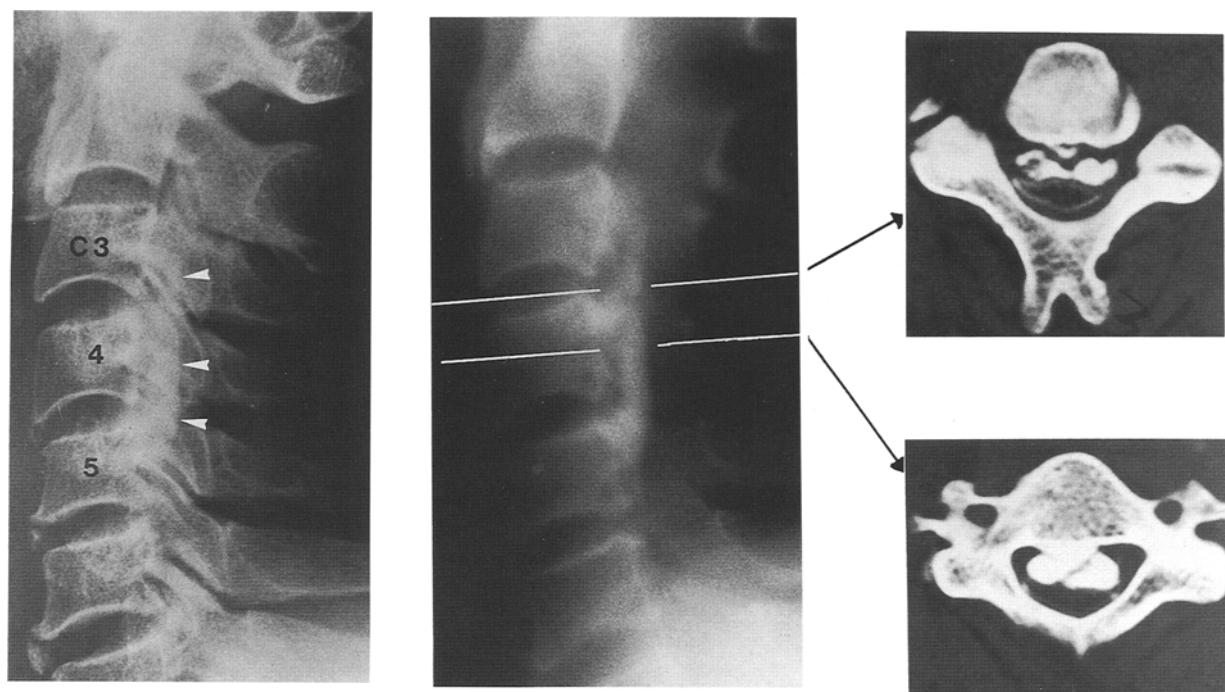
Morphology of OPLL. (Left column) Lateral view of the roentgenogram of the patient (case 3) showing noticeable abnormal radiopacity of OPLL along the posterior margins of vertebral bodies C3 to C5. (Middle column) Lateral tomogram of the same patient showing segmental OPLL starting at C3 and continuous to C4 and C5. (Right column) Preoperative CT-myelography showing that ossified PLL widely occupied the spinal canal and that the spinal cord was compressed by the ossified PLL. Top, C3/4 level; bottom, C4 level.
